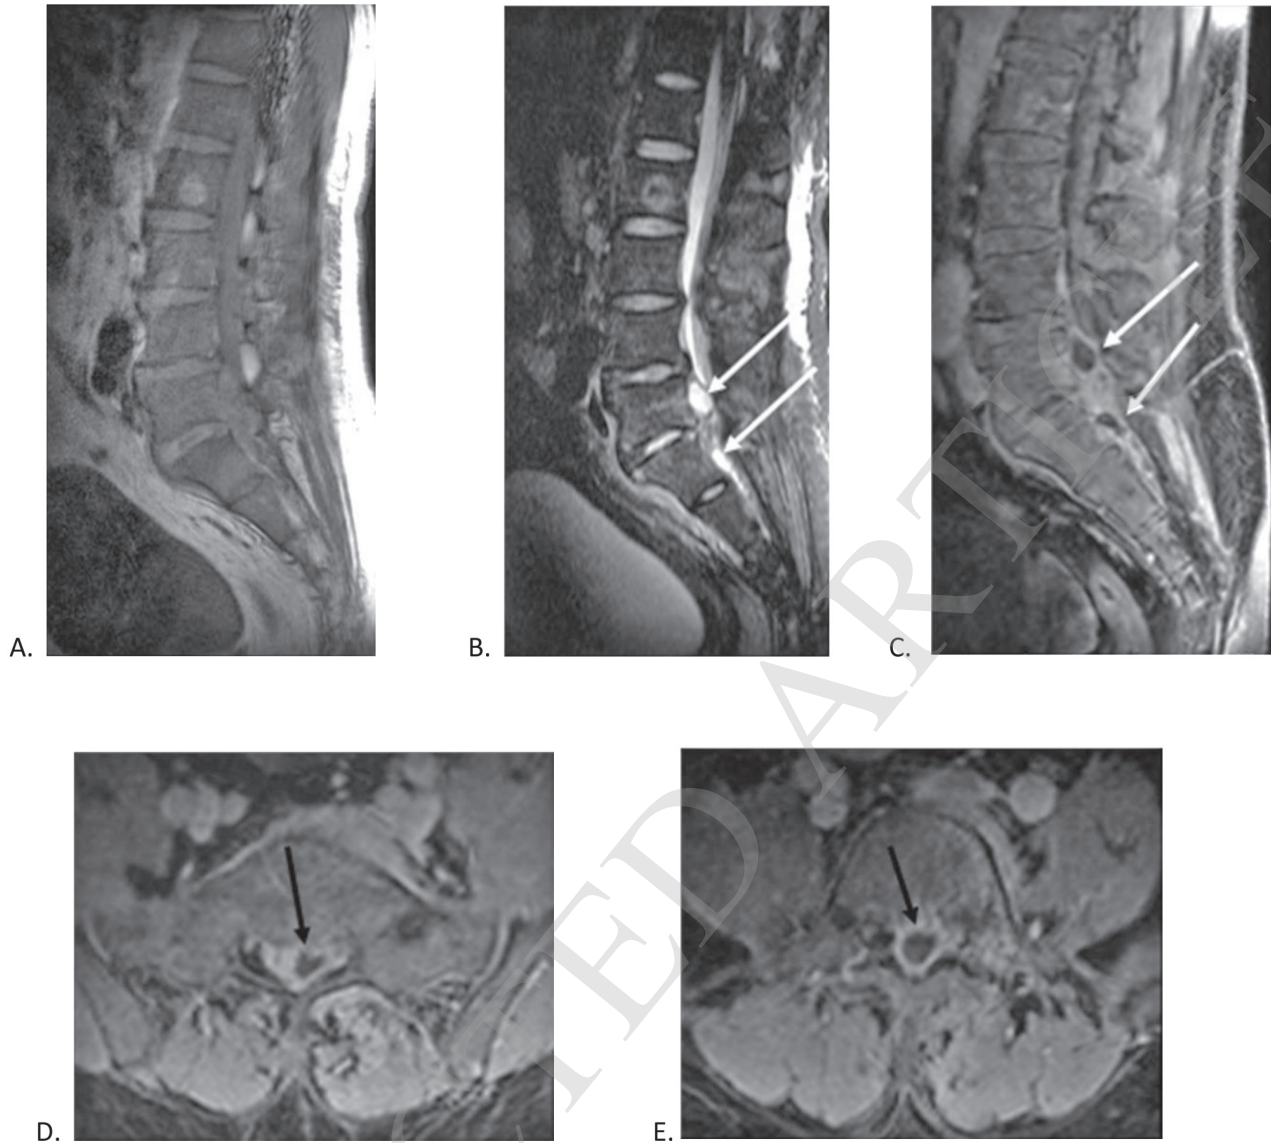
Pyogenic spondylitis with epidural abscesses. A 53-year-old male presented with fever and back pain for 3 weeks. A.T1- weighted sagittal MRI B.T2-weighted, fat-saturated sagittal MRI and C. Postgadolinium, fat-saturated T1-weighted sagittal MRI demonstrate abnormal T2 hyperintensity with some enhancement in the L5-S1 disc space as well as T2 hyperintensity with marrow enhancement in the L5-S1 endplates indicating spondylodiscitis. There are enhancing anterior epidural and anterior paraspinal soft tissues extending from the upper L4 level down to the end of thecal sac. Note a few nonenhancing T2 hyperintense fluid collections (white arrows) within enhancing anterior epidural soft tissue, representing epidural abscesses. D.and E.Postgadolinium, fat-saturated T1-weighted axial MRI also demonstrate two anterior epidural abscesses (black arrows) at the L5 and S1 levels compressing the thecal sac. An enhancing left-sided anterior paraspinal soft tissue phlegmon is noted. The epidural abscesses were surgically evacuated, and *S. aureus* was cultured.
